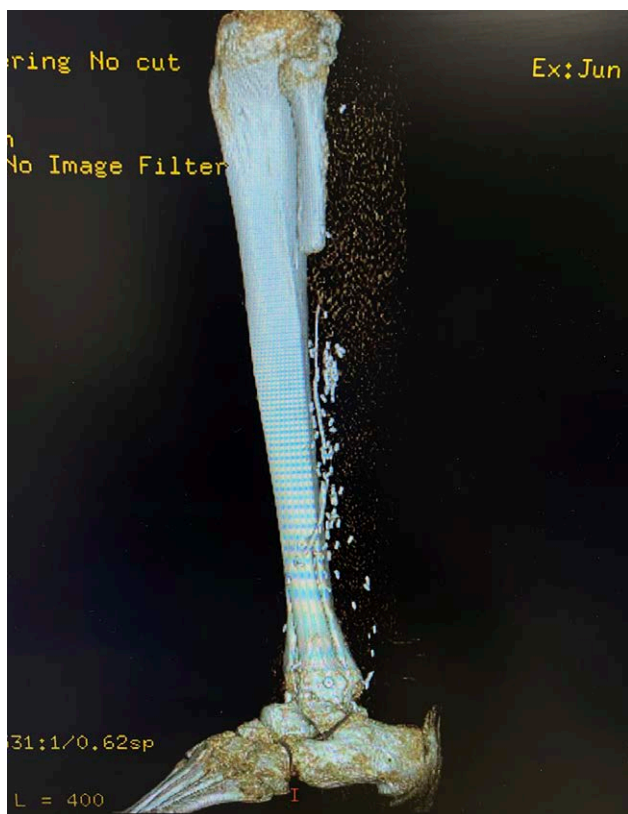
Case 5. Postoperative three-dimensional CT scan demonstrates placement of the fibula flap in the bone slot for ankylosis.
